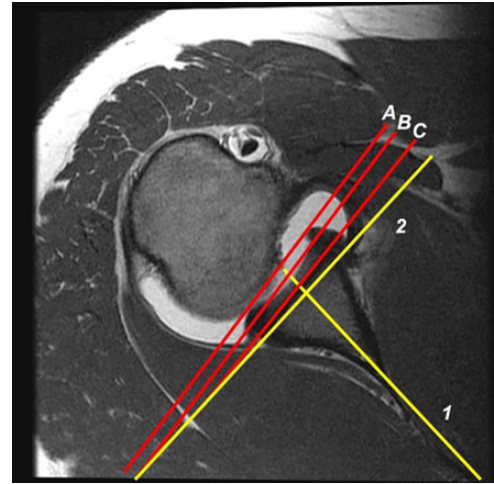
Axial magnetic resonance imaging scan with respective glenoid version measurements: First, a scapular reference line (1) is drawn from the middle of the glenoid to the medial scapula. Version was measured relative to a line perpendicular (2) to the scapular reference line. Labral version (A) was measured as the angle between a line connecting the apex of the anterior and posterior labrum and line 2. Chondral version (B) was measured as the angle line connecting the apex of the chondral surfaces at the chondrolabral junctions anteriorly and posteriorly and line 2. Bone version (C) was measured as a line connecting the apex of the subchondral bone anteriorly and posteriorly and line 2 (Reprinted with permission from Mauro et al¹⁹).
